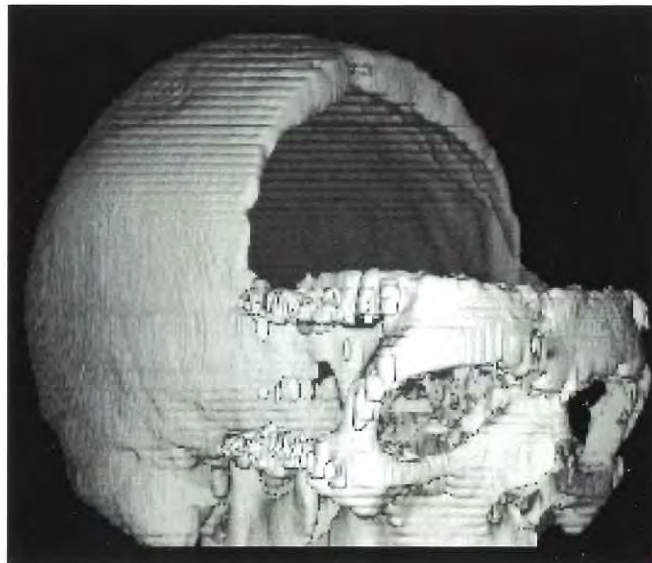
Post-operative 3D CT reconstruction of a patient with Crouzon syndrome showing complete loss of the frontal bone following Fronto-Facial Advance.
